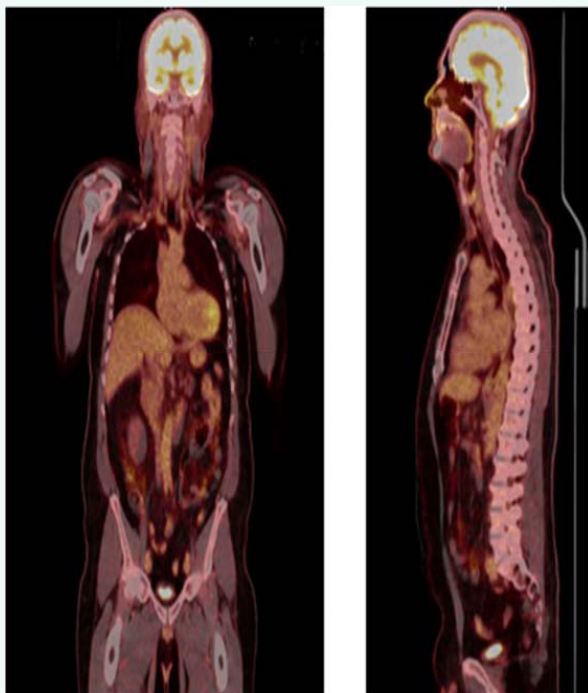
PET/CT coronal and sagittal images.
